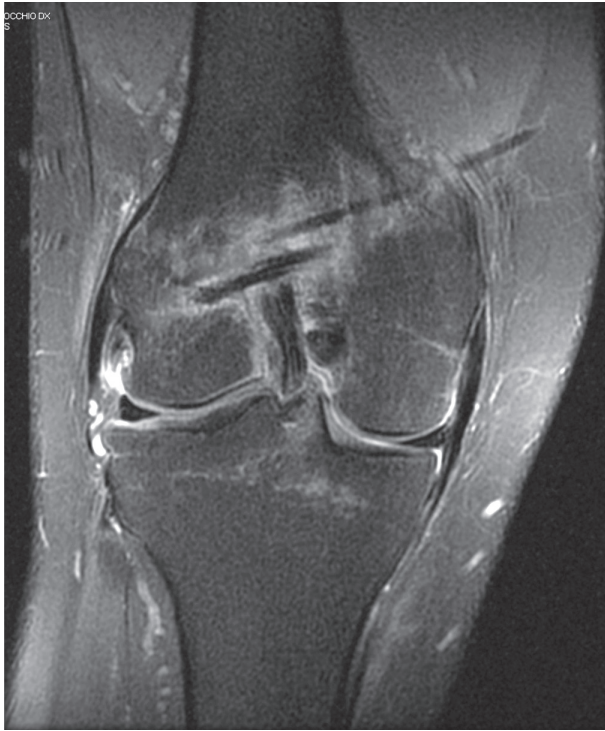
MRI STIR image shows the pin in soft tissues over the proximal femoral pin's tunnel
